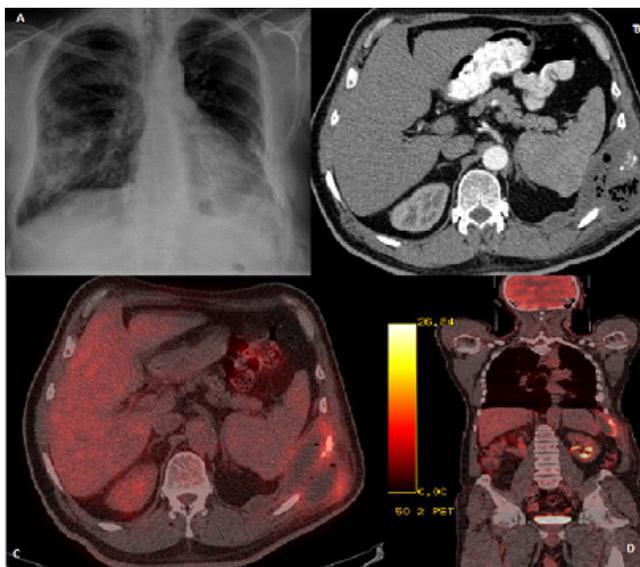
Fracture line at 8th rib on chest X-ray(A), The appearance of the mass including necrotic regions with bone destruction on thorax CT (B), The mass with mean uptake of 5.5 SUVmax at left thoracic wall on PET-CT (C,D).
